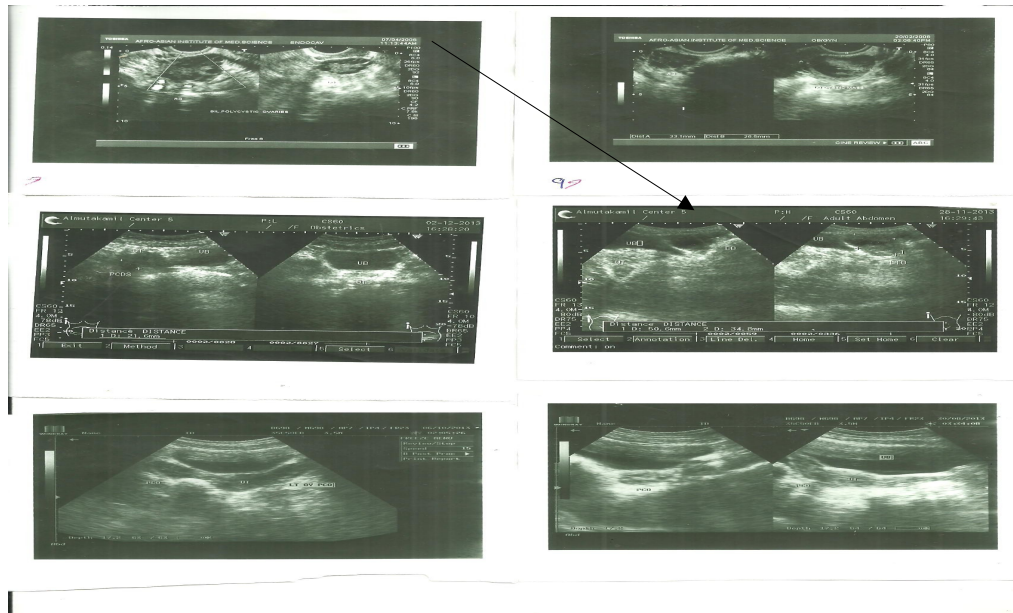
Figure Seven: 43 old Ultrasound show polycystic ovary
